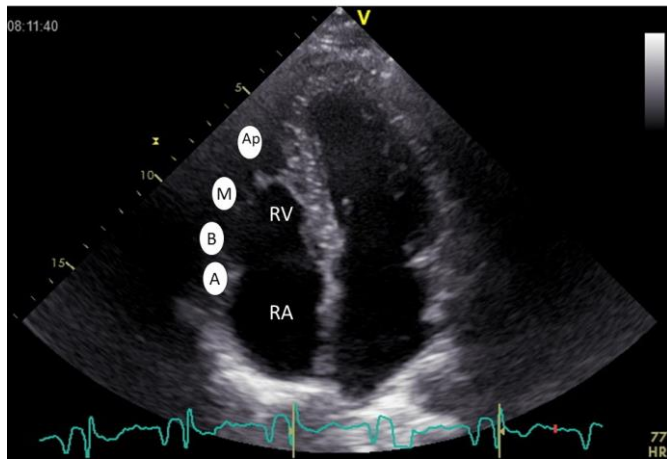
3 Echocardiographic views of the right ventricle (RV).
